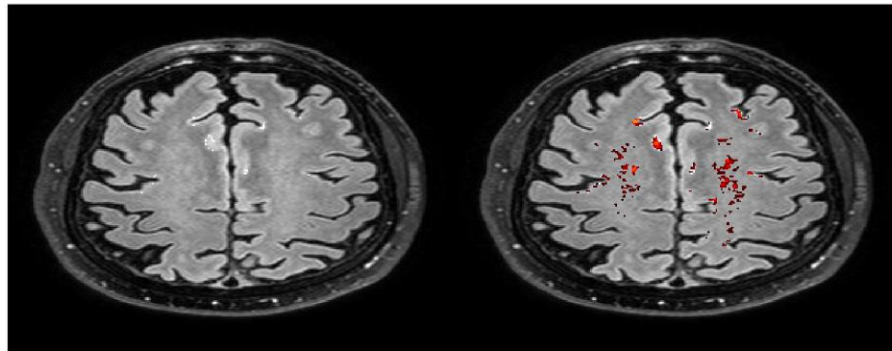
LST-produced FLAIR Image for RHI subject.* Axial slice at the level above the ventricles for an RHI subject. The subject has a history of CCS, including American football and ice hockey. The left image represents the FLAIR image and the right is the overlay of the segmentation of the FLAIR image with WMHs in red and yellow. The individual's WMH volume = 6 across 20 total lesions.
